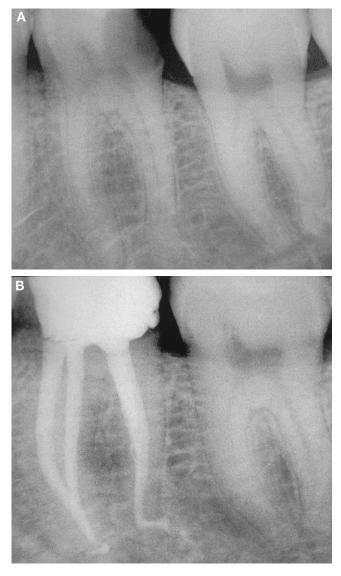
Tooth No. 19 showing 90° apical curve. (A) Preoperative radiograph. (B) Postoperative radiograph.
